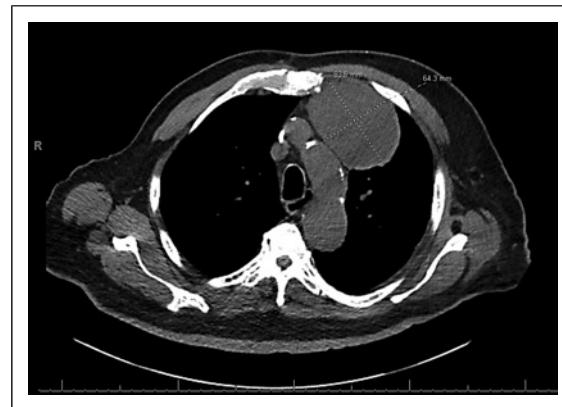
Axial CT chest showing progression of mediastinal mass measuring 83.6 mm by 64.3 mm.
